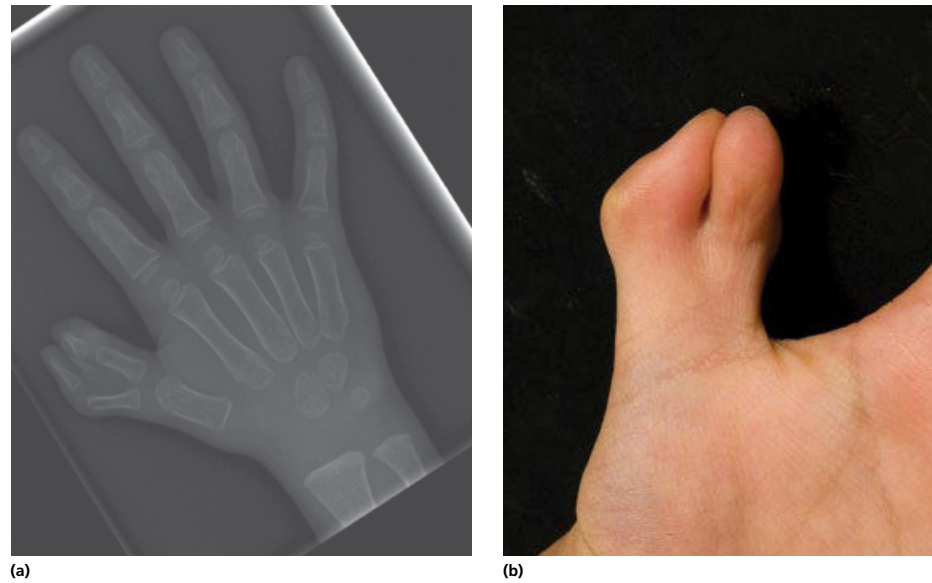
Wassel IV thumb duplication. (a) Radiographic image of a balanced Wassel type IV duplication demonstrating duplication from the proximal phalangeal distally. (b) Image of a patient with a Wassel type IV thumb duplication.
